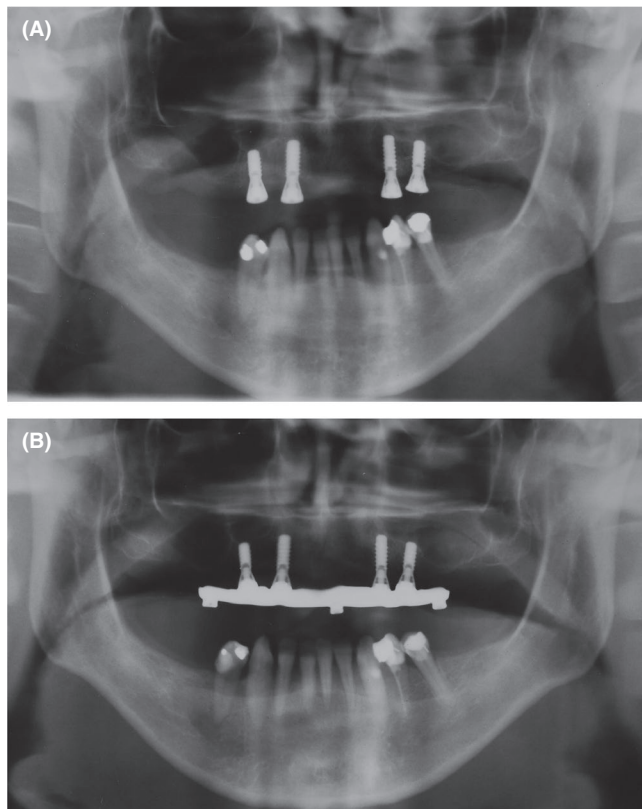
Follow-up radiographic evaluation. A, 4-mo postsurgery follow-up orthopantomography displaying good osseointegration. B, 6-mo postdenture insertion follow-up orthopantomography
